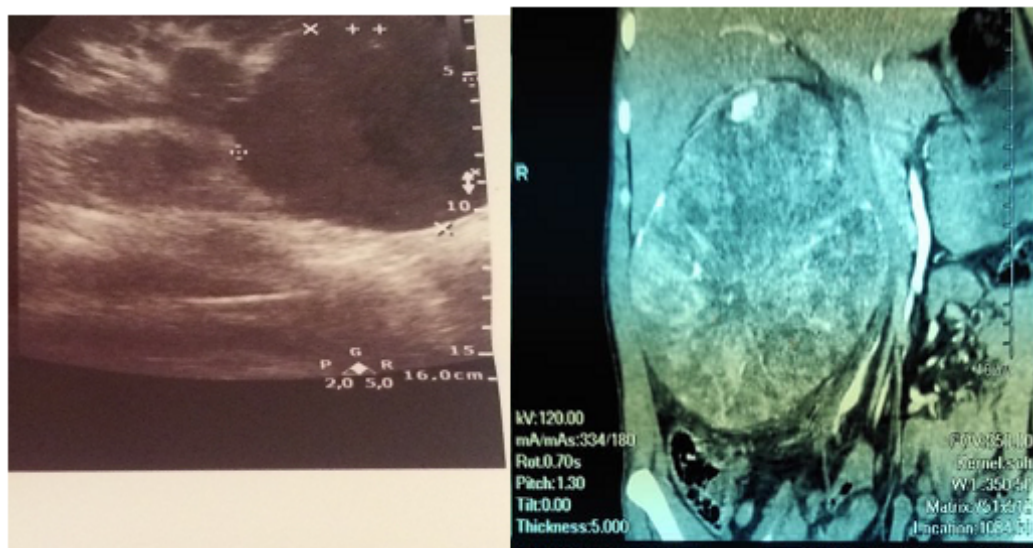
(A) Ultrasound aspect of renal mass (B) CT scan showing a right tumor in one of our patients.
